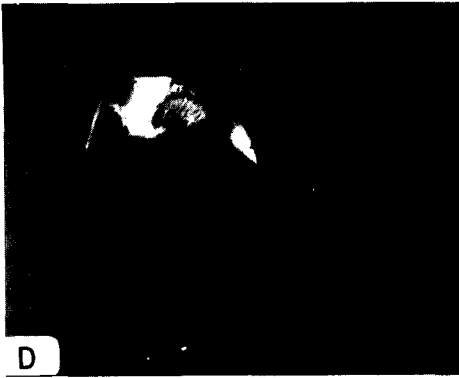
A. A 49-year-old woman with idiopathic thrombocythemia presented with pain in the left hip for 10 months followed by pain in the right hip within a few months. The radiographs of both hips show segmental collapse, more marked on the left as compared with the right. A moderate degree of degenerative arthritis is present.
